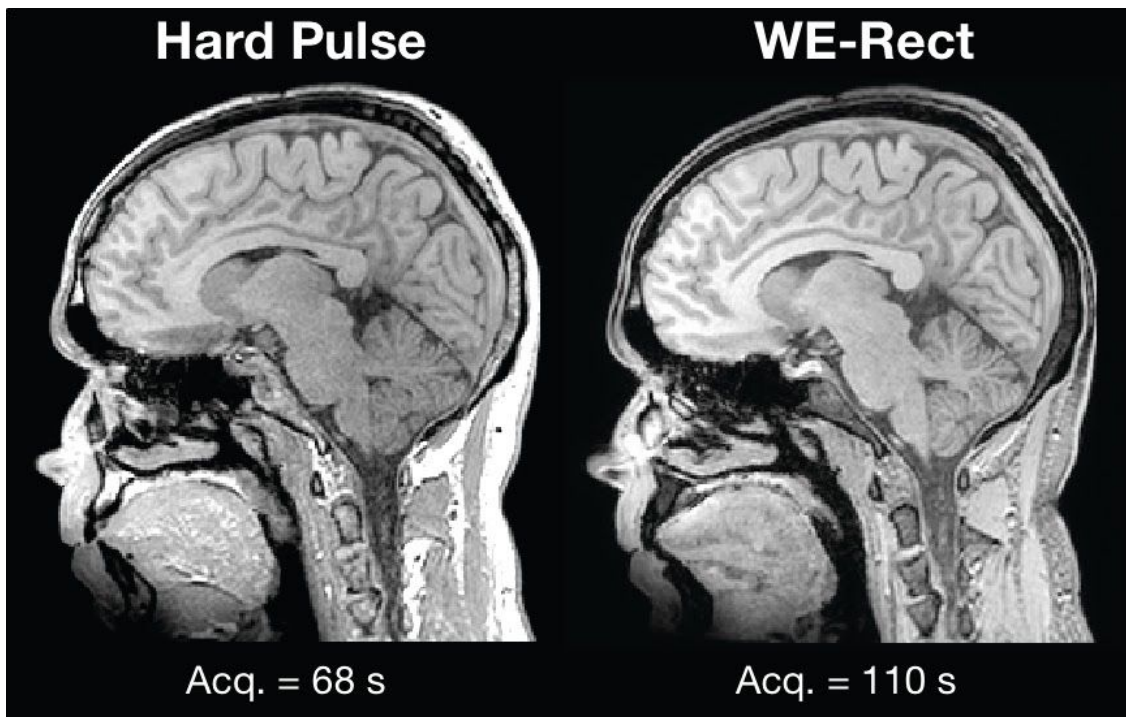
Two T1-weighted SPGR acquisitions where the left uses a short hard pulse and the right uses a WE-rect.
